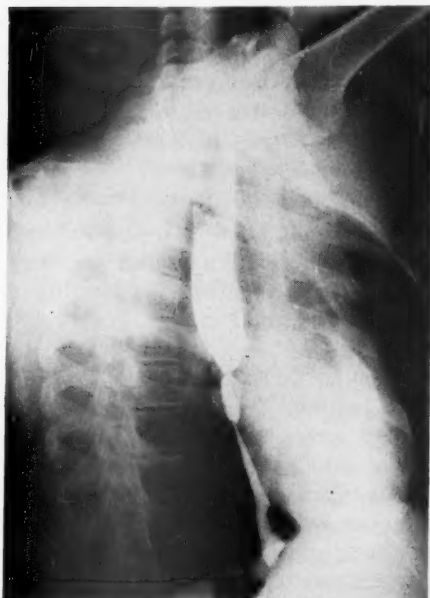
Roentgenogram of the esophagus with barium, showing multiple strictures in the lower half. The proximal portion is slightly dilated.
